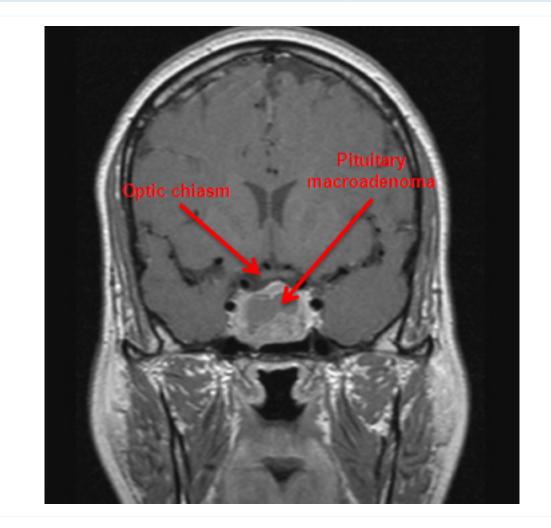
Gadolinium-enhanced magnetic resonance imaging showing a large pituitary macroadenoma in a 45-year-old man with hyperprolactinaemia
